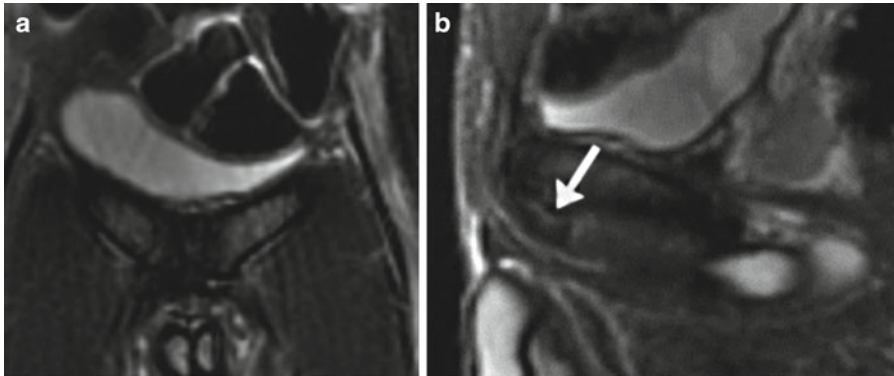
MRI rectus tendon injury on the left side. (a) Axial view; (b) sagittal view. *Arrows* point to the site of the tear/separation
